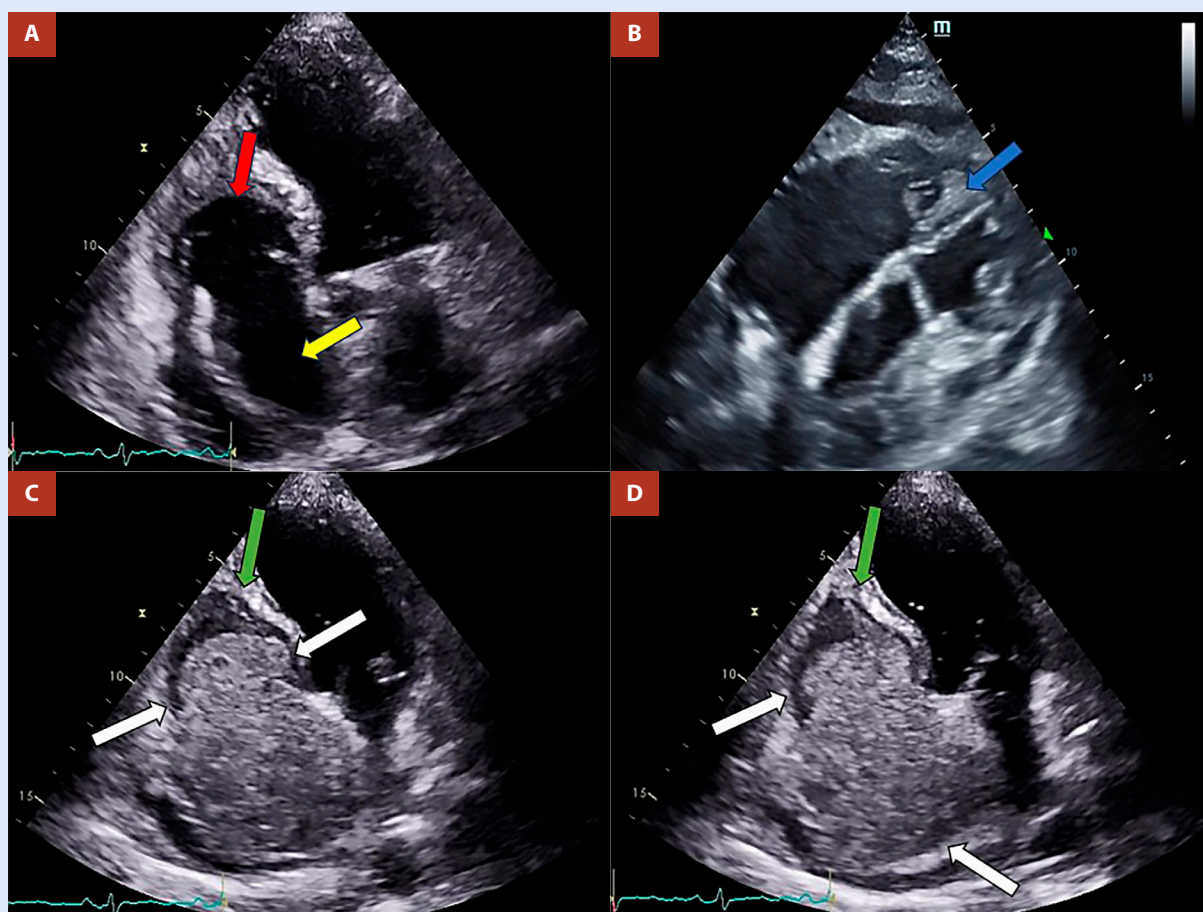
Transthoracic echocardiogram. Obliteration of the right ventricle (1A, red arrow), increased density of the moderator band (1B, blue arrow), endomyocardial plaques >2 mm thick (1C, green arrow), dilation of the right atrium (1A, yellow arrow) without involvement of the left ventricle. The agitated saline test clearly defined the endocardial border (1C-D, white arrow).
